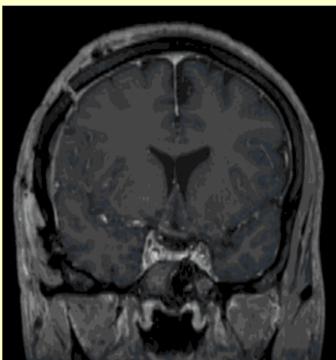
Coronal MRI 3 months post op showing resolution of epidural and optic nerve enhancement
